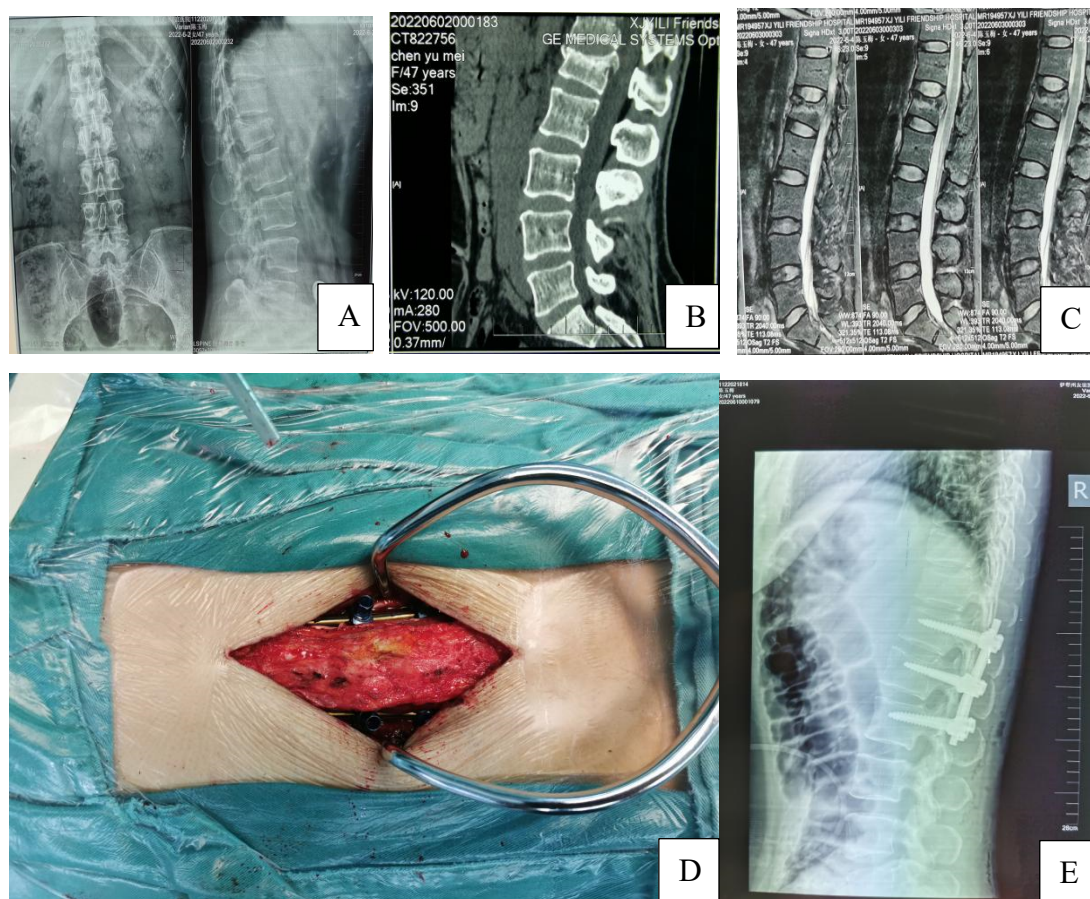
Minimally invasive Wiltse approach to open reduction and pedicle screw internal fixation to treat lumbar spine fractures. (A) Preoperative X-ray (B) Preoperative sagittal CT (C) Preoperative MRI (D) Implantation of pedicle screws through the Wiltse paravertebral muscle space approach (E) Postoperative X-ray
